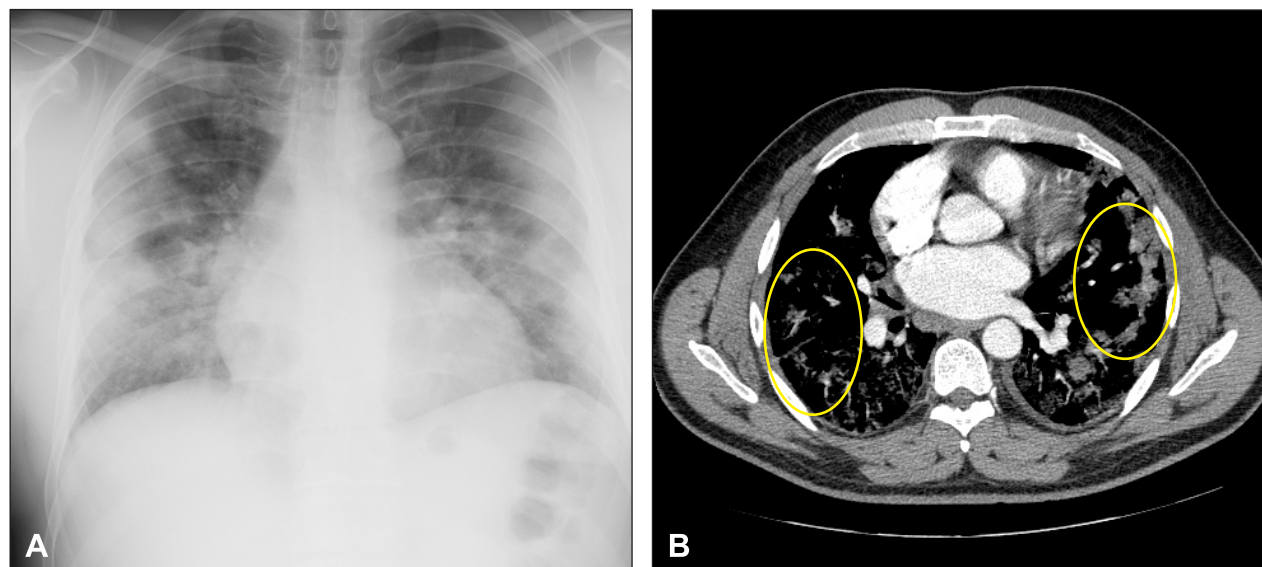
Chest X-ray on admission demonstrates bilateral pulmonary infiltrates (A). Chest CT scan showing typical CT findings of COVID-19: bilateral peripheral ground-glass opacities in the lungs (B, circle).
